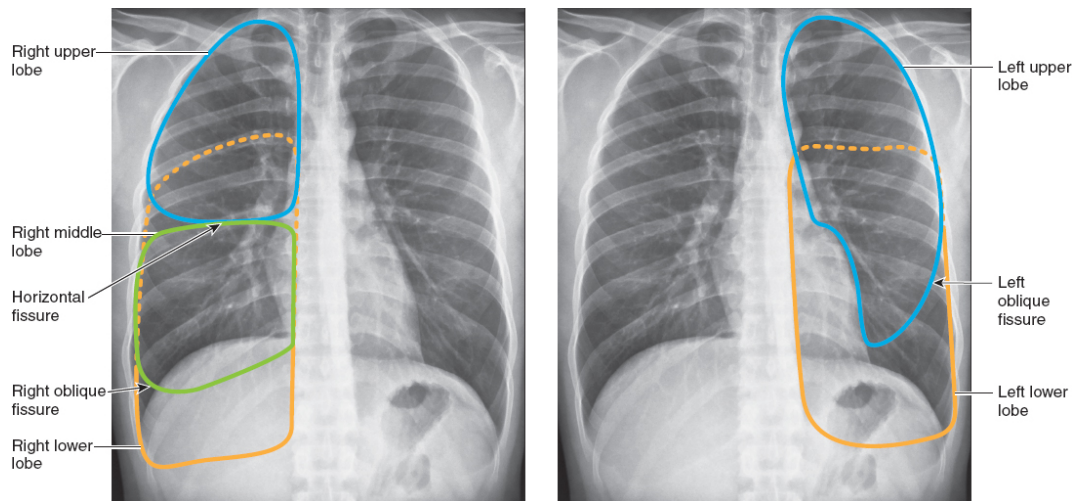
Right and left lungs in anterior view of a chest radiograph. (From Brant WE, Helms CA. *Brant and Helms Solution: Fundamentals of Diagnostic Radiology*. 3rd ed. Lippincott Williams & Wilkins; 2007, Fig. 1-5.)
